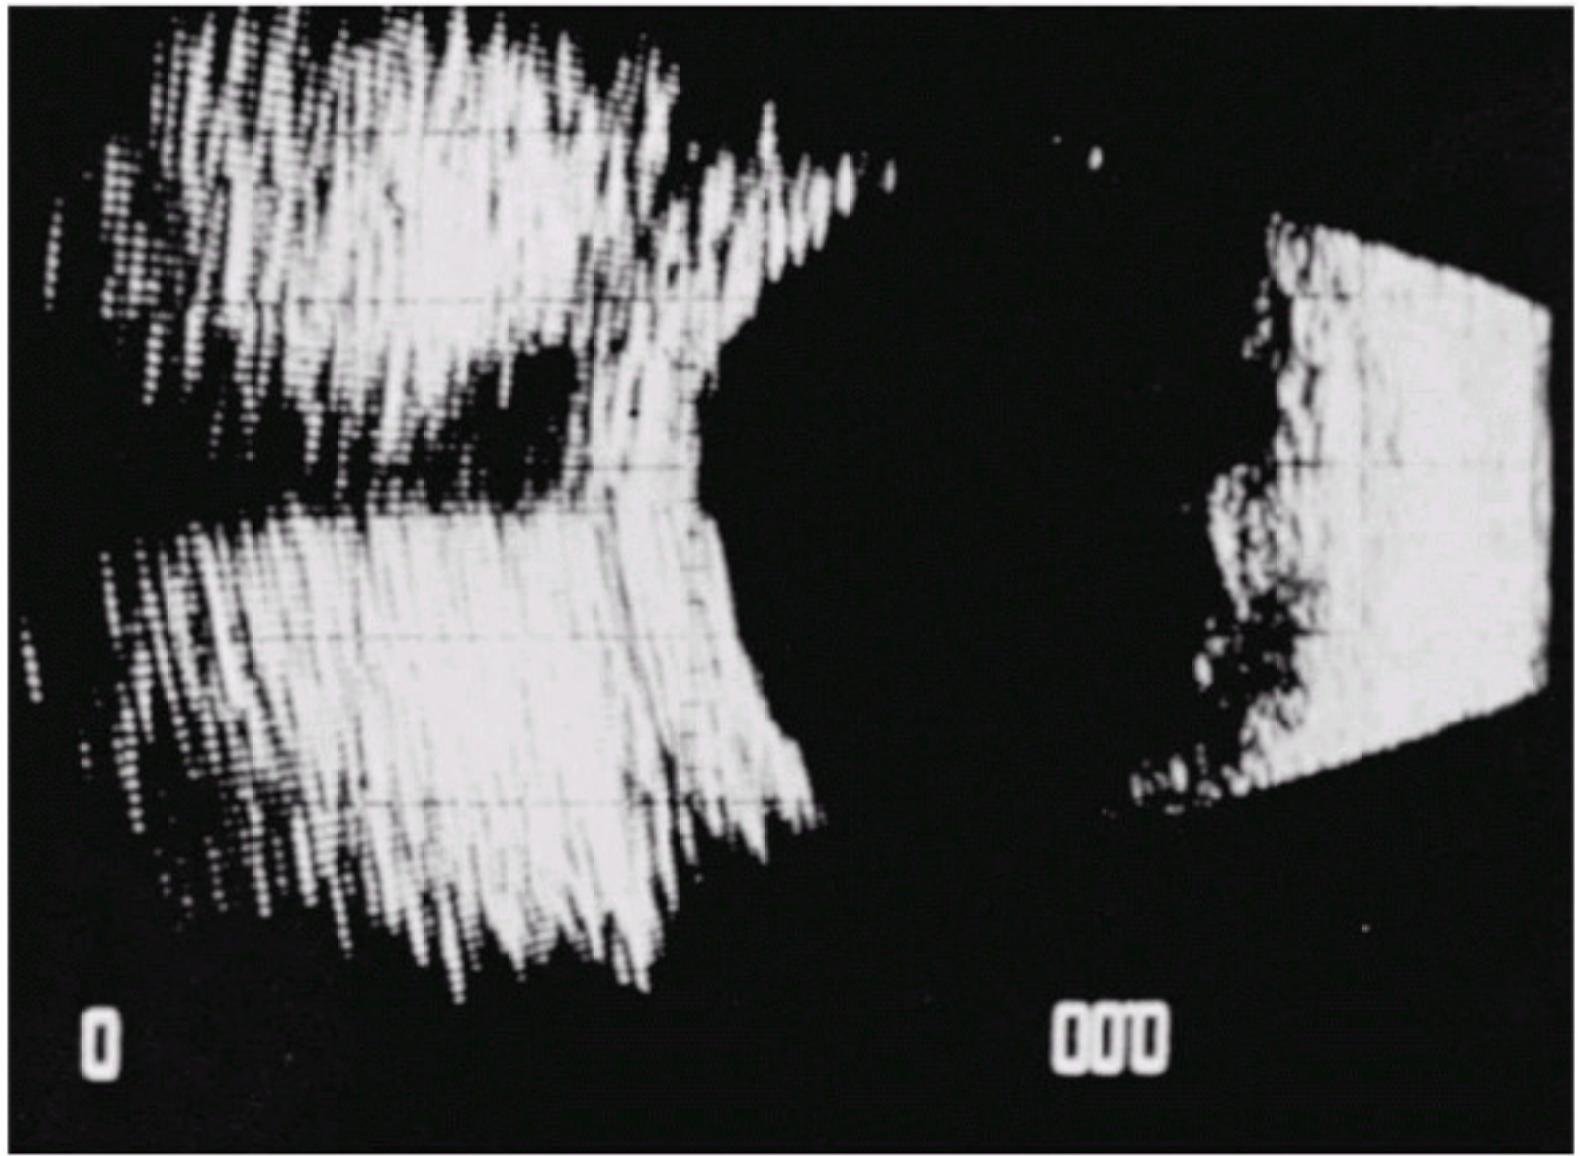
Idiopathic orbital inflammation showing scleral and choroidal thickening, known as the ring sign on computed tomography scan.
